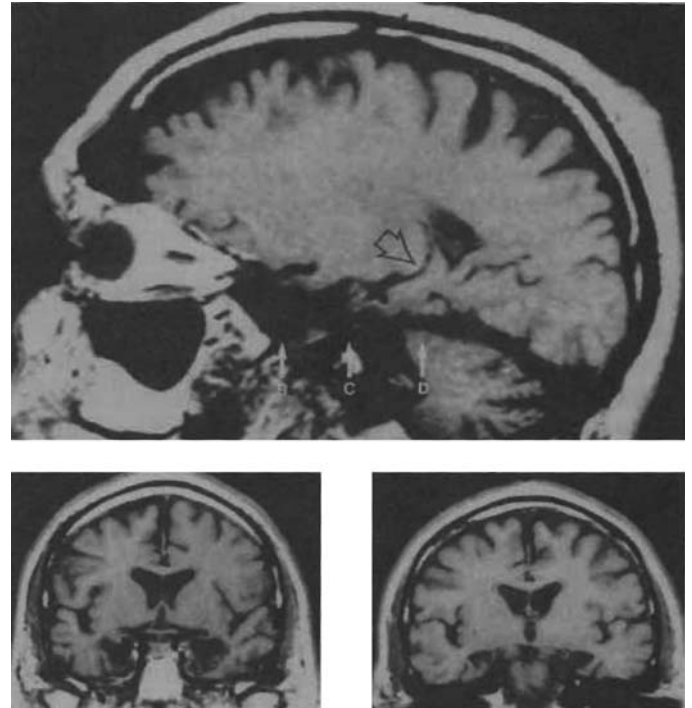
Hippocampal damage in patient H.M., shown on a sagittal (top) and two coronal slices (below) of the patient's MRI.
